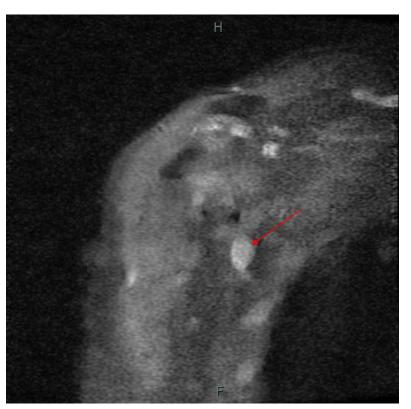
Post-contrast MRI of the chest coronal demonstrating incidental breast nodule with enhancement
